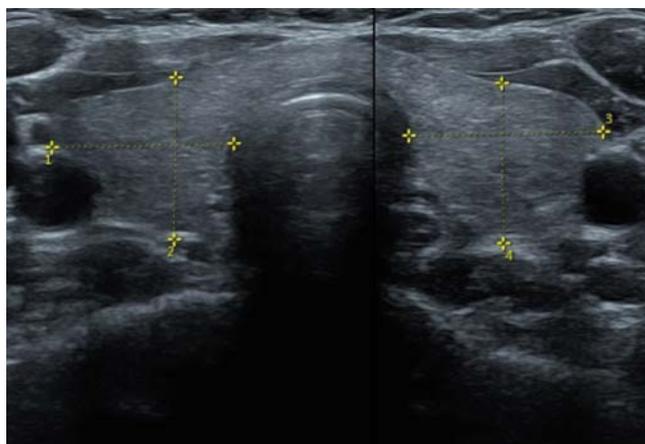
Sonogram presenting the width and the thickness of the thyroid lobes
